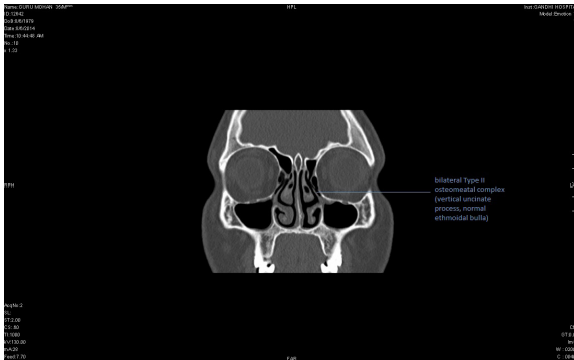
CT scan of Paranasal sinuses showing bilateral type II osteomeatal complex (Vertical type II unciniate process)
